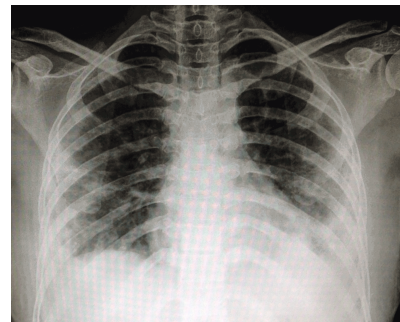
Admission X-ray showing bilateral illdefined alveolar shadows
